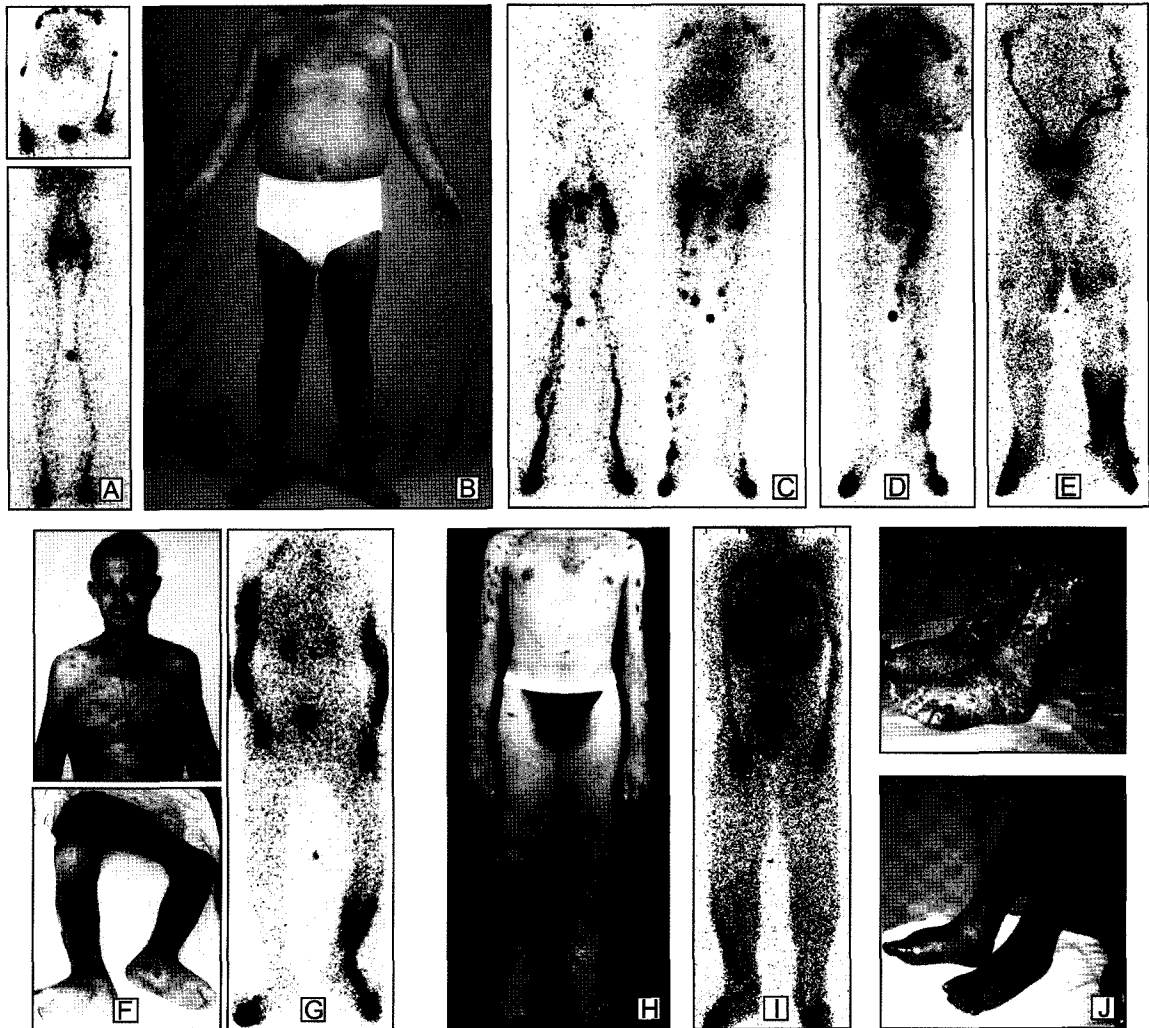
Evolution of clinical manifestations and lymphangioscintigraphic images of AIDS-associated Kaposi sarcoma with peripheral and torso lymphedema. A: Normal whole body lymphangioscintigram of arms (upper frame) and legs (lower frame). Characteristic features are rapid tracer (^{99m}Tc -human serum albumin) transport without tracer dispersion (dermal backflow), and visualized regional nodes ("hot spots"). In these images, a small amount of tracer excretion into the urinary bladder is seen. Small midline "dots" represent location markers (e.g., knees, pubis, xiphoid, sternal notch). B: 43-year old homosexual male with bilateral leg lymphedema and Kaposi sarcoma-associated AIDS skin lesions. C-E show initial lymphangioscintigraphic appearance and progression of lower extremity lymphatic dysfunction (upper extremities show minimal change) over a 5-year period. C: Prompt tracer transport with focal "highlights" of tracer along calf and thigh corresponding to the sites of Kaposi lesions. During the subsequent five years (D,E), lymphatic obliteration has continued with limited tracer transport in left leg, little or no tracer migration in the right leg, and pronounced dermal backflow in both lower extremities. F: Disseminated mucocutaneous AIDS-associated Kaposi sarcoma in a 35-year old male homosexual with marked facial, torso, upper and lower extremity lymphedema. G: Whole body lymphangioscintigram showing dermal backflow without visualization of regional lymph nodes (axillary or groin) consistent with severe lymphangiodysplasia and high grade lymphatic obstruction/obliteration (compare with A). H: Advanced cutaneous AIDS-Kaposi sarcoma associated lymphedema of the legs in a 44-year old homosexual male. I: Lymphangioscintigram of patient shown in H demonstrating little or no tracer transport with pronounced distal dermal backflow (compare with A). J: Patient shown in H before (upper frame) and 6 weeks after (lower frame) extensive cleansing of skin, leg elevation with compressive bandaging-manual massage and topical antifungal and antimicrobial agents. Note the marked improvement in edema, skin texture, and overall appearance facilitating mobility.
